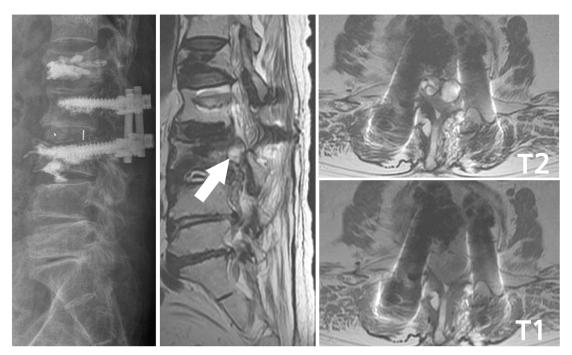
Initial imaging showing reactive changes of epidural space after spinal surgery. T2 weighted sagittal MRI scan showed a cystic lesion at the site of L2-3 epidural space (white arrows). Axial MRI scans showed low signal intensity on T1-weighted image and hyperintensity on T2-weighted image.
